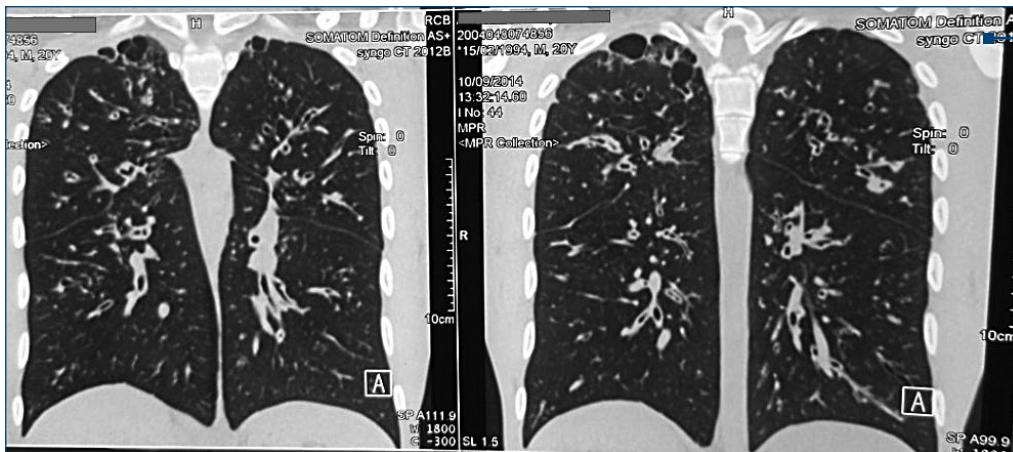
Patients CT scan (male, 17 years old)
